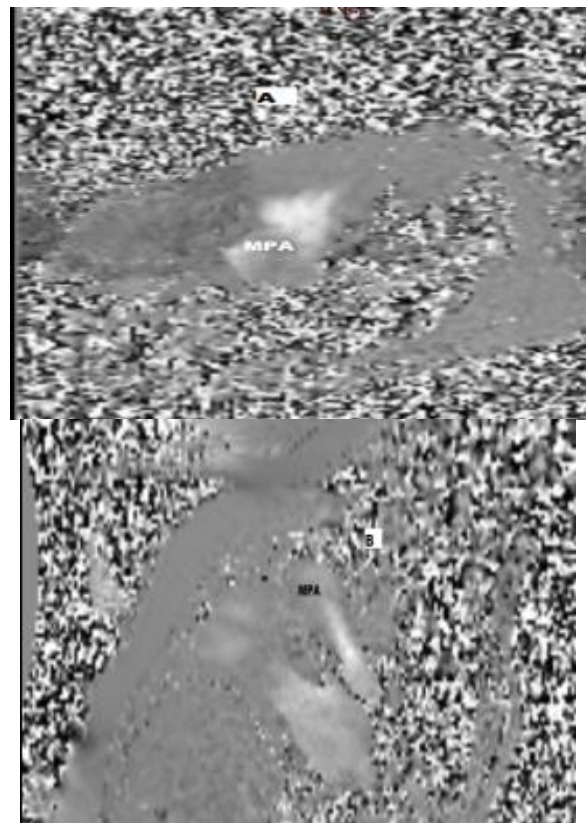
Cardiac MRI phase velocity study through MPA, (A) TP study for MPA, (B) IP study for MPA.
